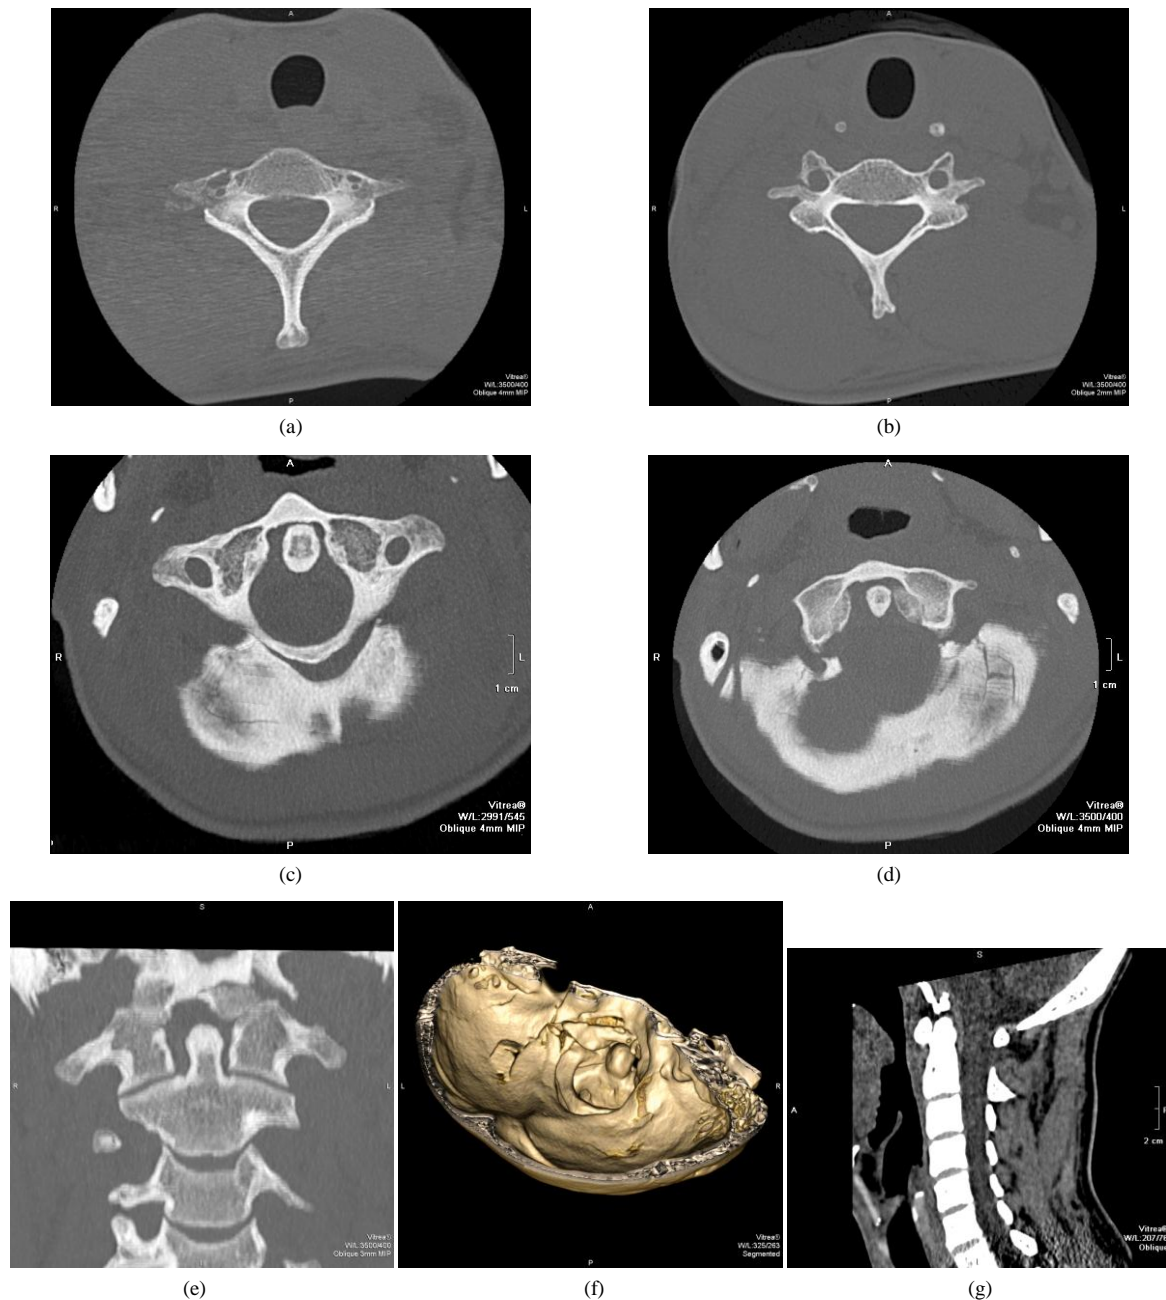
(a) and (b) MIP images of axial CT scan of the lower cervical spine in bone window at C7 (a) and C6 (b) levels show fractures of right transverse processes of the corresponding vertebrae (white arrows). (c) and (d) MIP images of axial CT scan of the occipital bones in bone window reveal fractures (black arrows). (e) Coronal reformatted CT scan in bone window shows fracture of left occipital condyle (open arrow). (f) 3D volume rendered image of the skull base in superior oblique view reveal fracture of left occipital bone extending into left occipital condyle (black arrowheads). (g) Sagittal image of the cervical spine in soft tissue window reveals hyperdensity just posterior to the clivus, extending down to the upper odontoid process, suggestive of acute hematoma (double white arrows).
